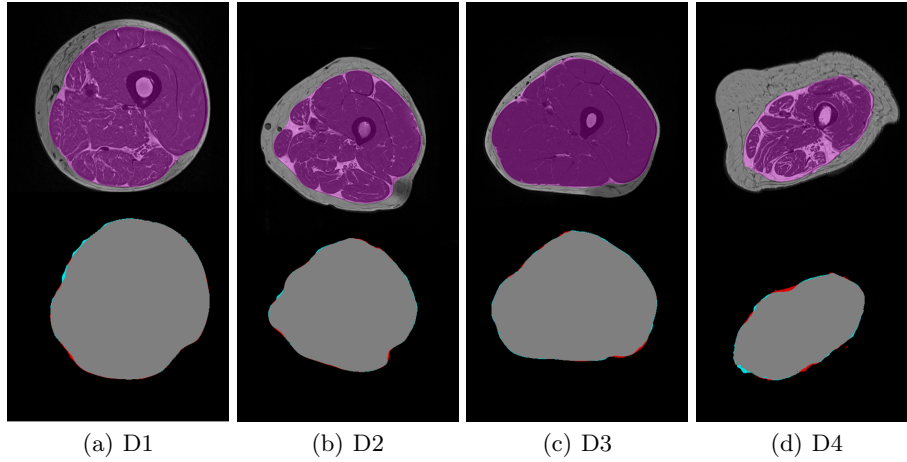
Top row: MR image with overlay of the prediction mask (magenta). Bottom row: gold standard mask (red), prediction mask (cyan) and intersection of both masks (gray).
